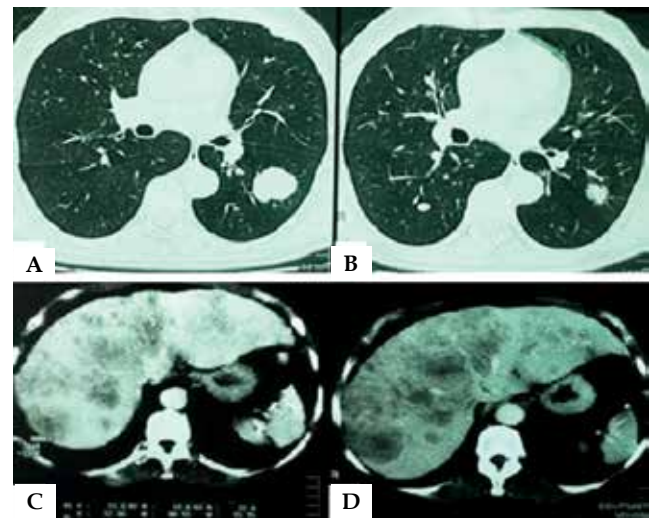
Chest and abdomen computed tomography. A and B: Multiple nodules in the lungs and a mass in the left inferior lobe. C and D: Multiple nodules in the liver
